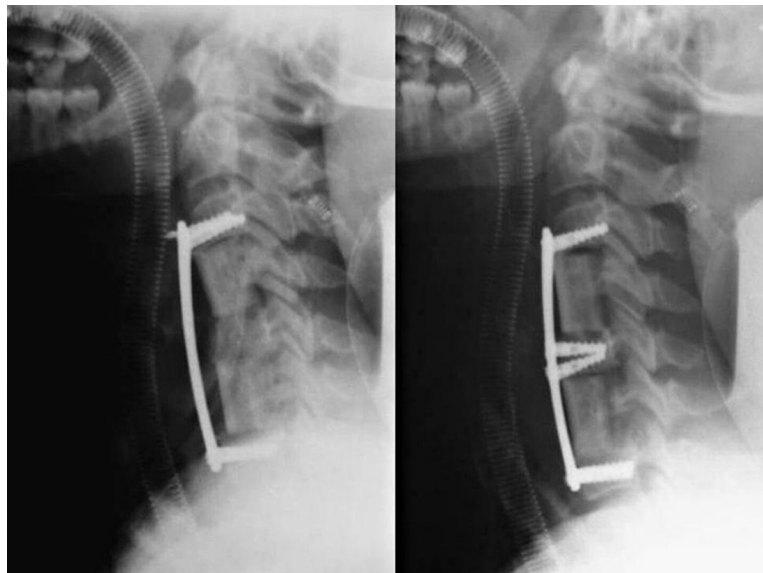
Radiograph indicating placement of screw into the middle vertebra, bringing the C5 vertebral body to the plate during the surgery.
